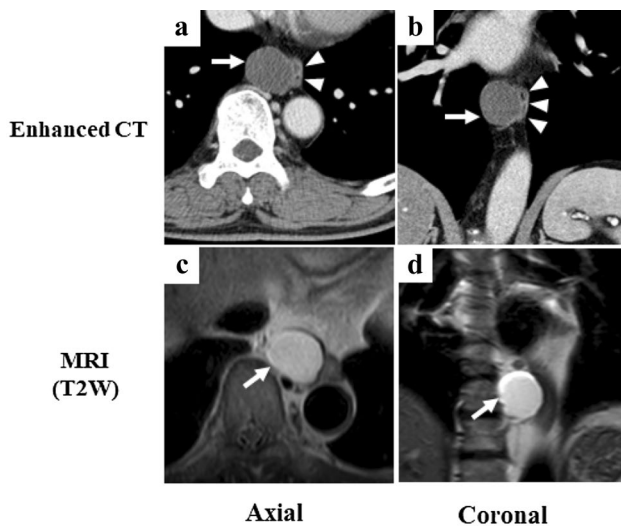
a, b Enhanced CT showed a well-defined homogenous lesion with 30 mm in size along the right side of the middle esophagus (arrows). The esophagus was compressed by the cyst (arrowheads). c, d T2-weighted magnetic resonance imaging also showed a 30-mm lesion with cystic fluid, but without any solid tumors, adhered to the esophagus (arrows)
